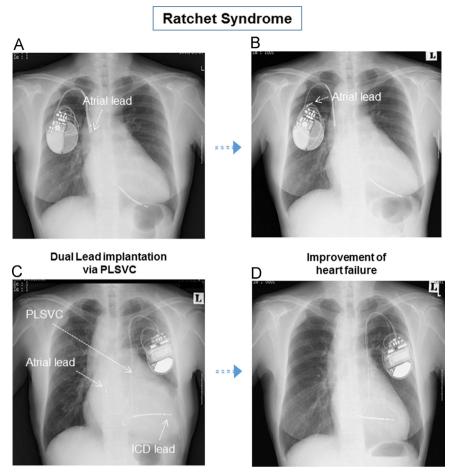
(A) A chest radiograph taken 2 months after the operation. The tip of the atrial lead is located at the mid portion of the superior vena cava (indicated by the arrow). (B) Full retraction of the atrial lead into the pocket (arrow) at the time of subacute exacerbation of her heart failure. (C) The alpha configuration of the implantable cardioverter defibrillator lead and atrial lead implanted via the persistent left superior vena cava (PLSVC). (D) Dramatic improvement in heart failure after the successful dual lead implantation, with complete atrial pacing and without any ventricular pacing.
